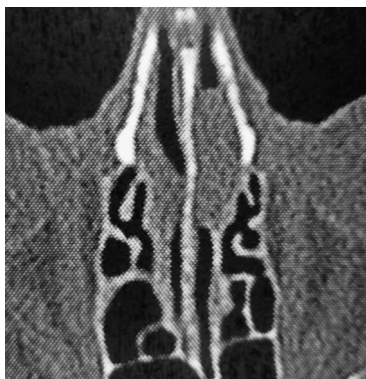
Axial CT scan indicating an unusual tissue mass in the olfactory cleft region bilaterally, particularly on the right.
